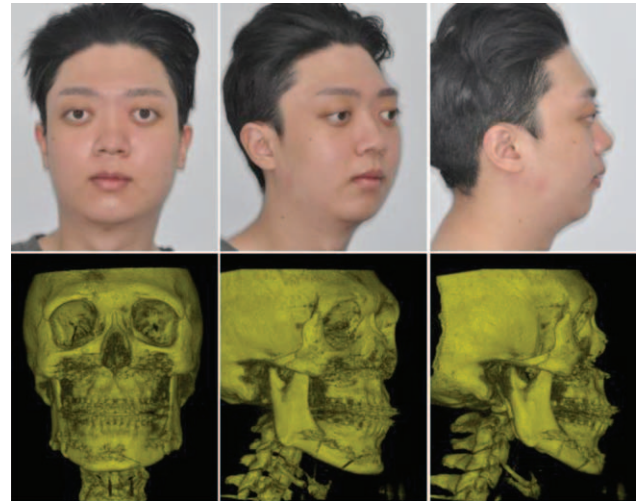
Clinical photos and radiographs after orthognathic and patient-specific implant graft surgery. Proper occlusion was achieved through orthognathic surgery, and midface deficiency along with exophthalmos and ocular ptosis was improved through a radiolucent patient-specific implant.
